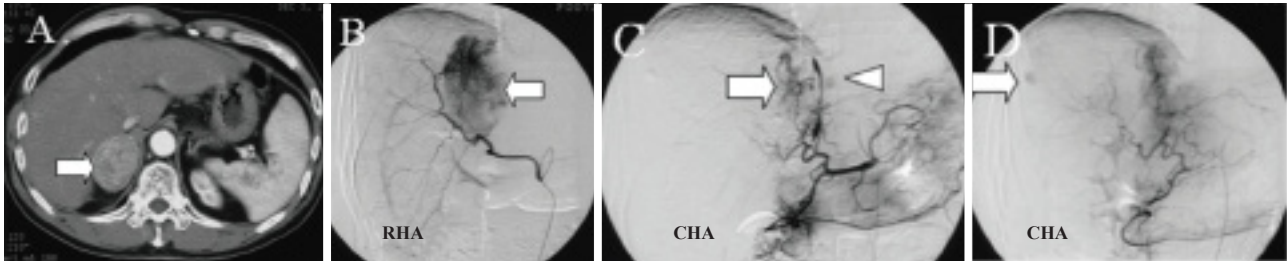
A: A metastatic hepatocellular carcinoma lesion (arrow) seen in the right adrenal gland during the early phase of contrast-enhanced dynamic computed tomography; B: A tumor (arrow) detected in the right adrenal gland on a right hepatic arteriogram (RHA); C: A tumor (arrow) noted in the right adrenal gland, and a faint tumor (arrowhead) observed in segment 4 of the liver on a common hepatic arteriogram (CHA); D: A faint tumor (arrow) seen in segment 8 of the liver on a CHA.
